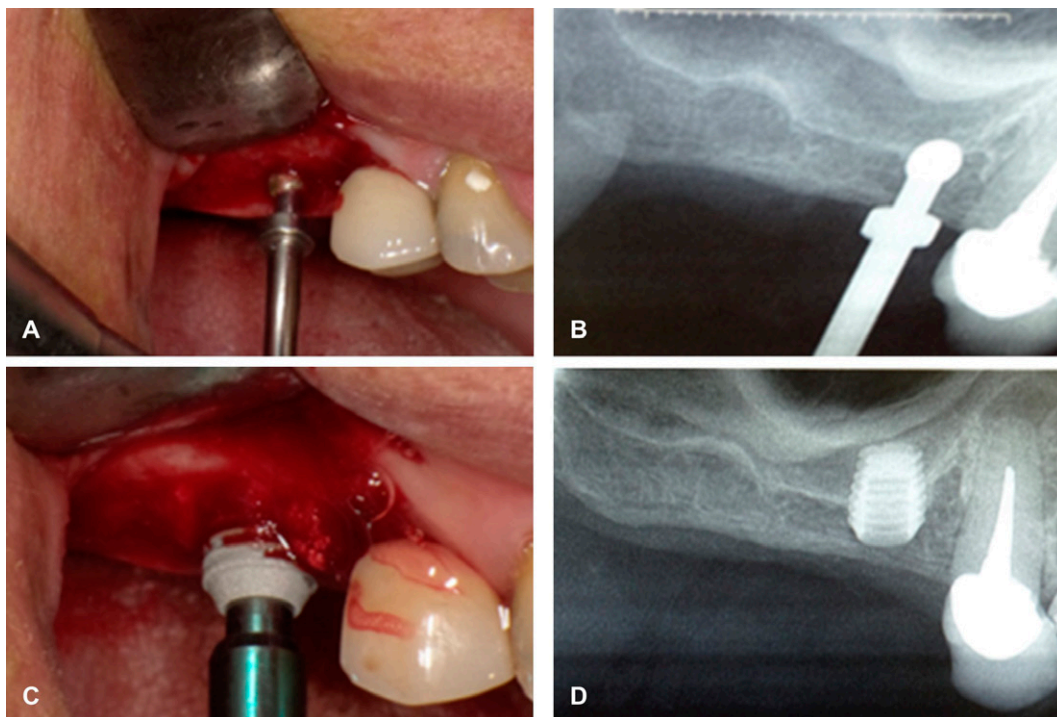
Surgical procedure. A. Surgical Site Preparation. B. Control digital Radiography of the preparation of the surgical site. C. Short dental implant placement. D. Final digital radiography with the short dental implant, without drilling the maxillary sinus.
